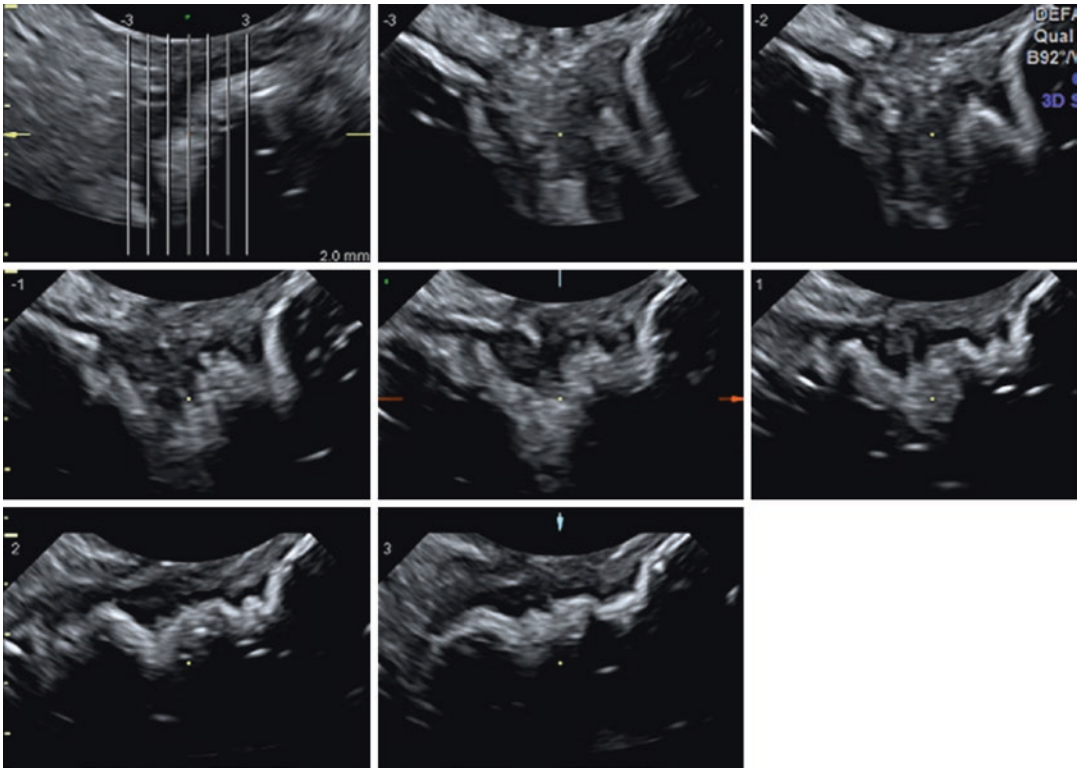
Tomographic ultrasound images obtained during rectal water contrast transvaginal ultrasound. This series of slices can provide information regarding the extent of infiltration of intestinal wall by endometriotic nodule
